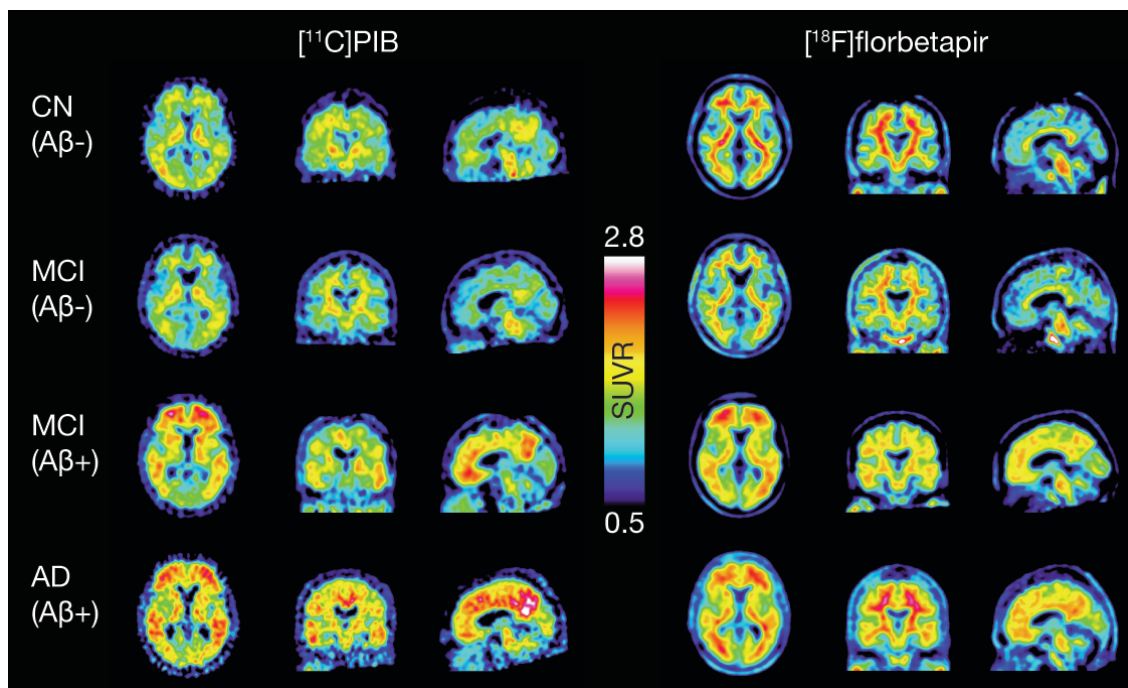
[^{11}C]PIB and [^{18}F]florbetapir SUVR images from age-, gender- and MMSE-matched cognitively normal volunteers (CN), patients with MCI (A β -negative and -positive) and patients with probable AD. The figure is adapted from Chiotis, K. *et al.* Amyloid PET in European and North American cohorts; and exploring age as a limit to clinical use of amyloid imaging. *European journal of nuclear medicine and molecular imaging* 42, 1492-1506, (2015).
